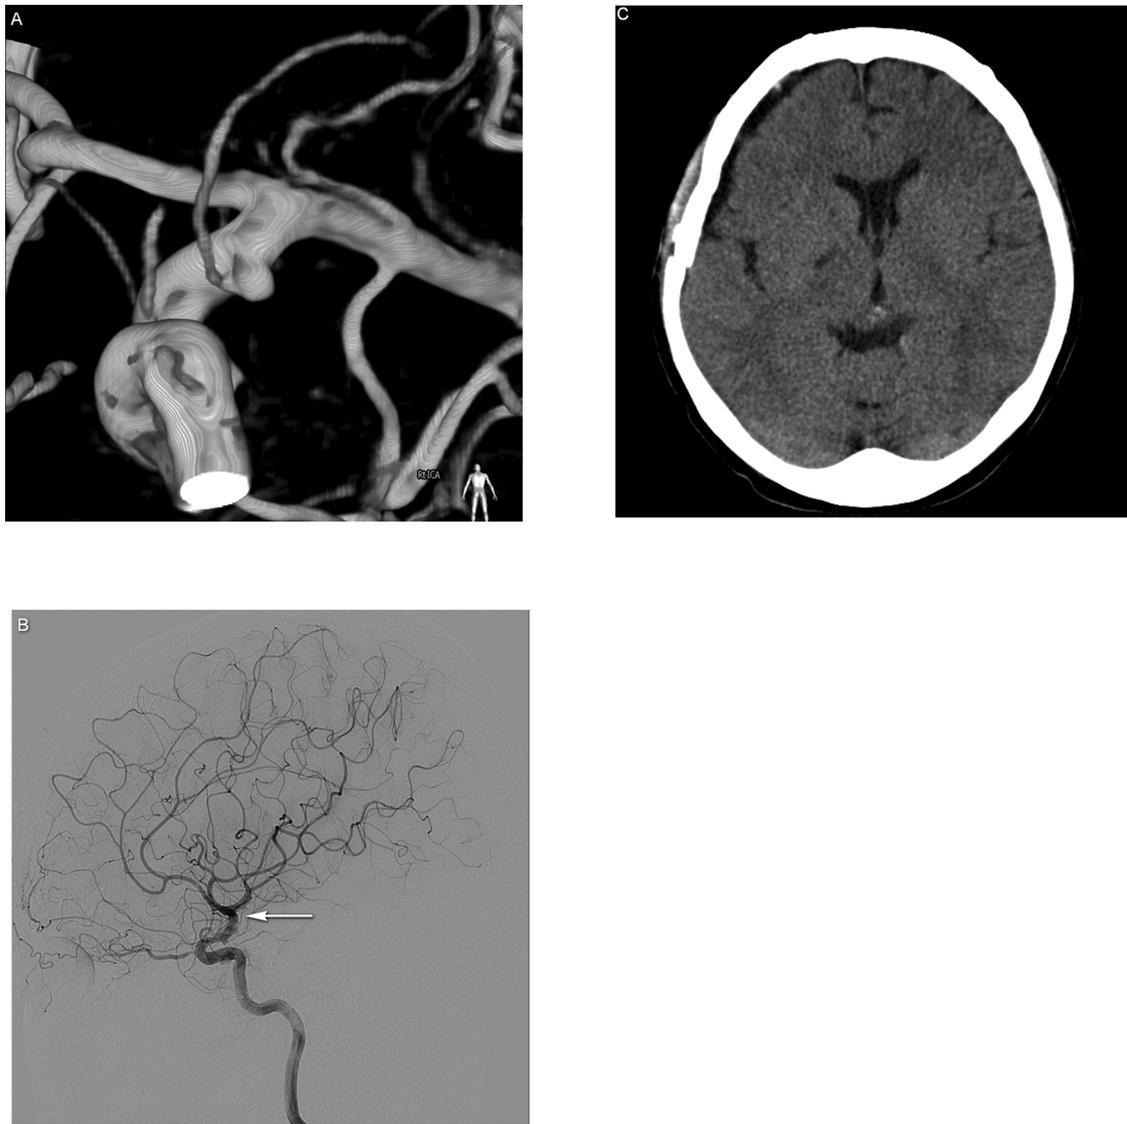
(A) A 48-year-old woman had multiple unruptured intracranial aneurysms including in the right anterior choroidal artery (AChA) (2.8 mm), the right superior cerebellar artery (SCA) (2.3 mm), the left internal carotid artery bifurcation (ICAB) (1.2 mm), the M1 segment (3 mm), and basilar artery bifurcation (BABIF) (2.8 mm) aneurysms without any symptoms. The left ICAB and M1 aneurysms had been clipped 4 months before. The right AChA, SCA, and BABIF aneurysms were clipped simultaneously. There were no abnormal findings regarding the intraoperative evoked potential monitoring during microsurgical clipping. Immediate post-operative mobile brain computed tomography (CT) results showed no unusual findings. The patient recovered from general anesthesia without any neurologic deterioration. (B) The post-operative digital subtraction angiography performed 5 days after surgery showed no abnormal findings, including an intact flow of the right AChA (white arrow). (C) However, a follow-up brain CT performed 7 days after surgery revealed an old infarction at the territory of the AChA including the right posterior limb of the internal capsule and hippocampal head. The patient was discharged 8 days postoperatively without any neurologic deficits and a modified Rankin Scale score of 1.
